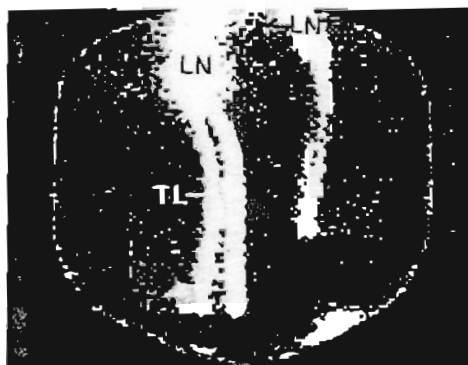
Articular lymphoscintigraphy ( $^{99m}\text{Tc}$ -labeled dextran) demonstrating lymphatic drainage channels at 6 hours in a patient with bilateral osteoarthropathy more severe on the right side. LN = lymph nodes; TL = lymphatic channels.
